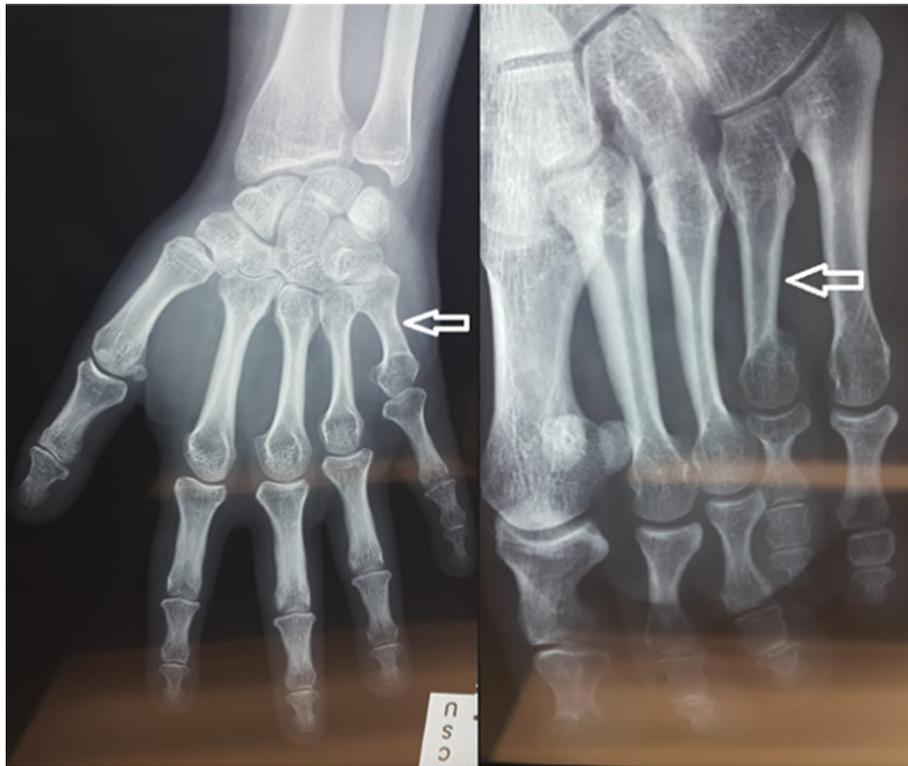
X-ray showing the shortened metacarpal and metatarsal bones.
